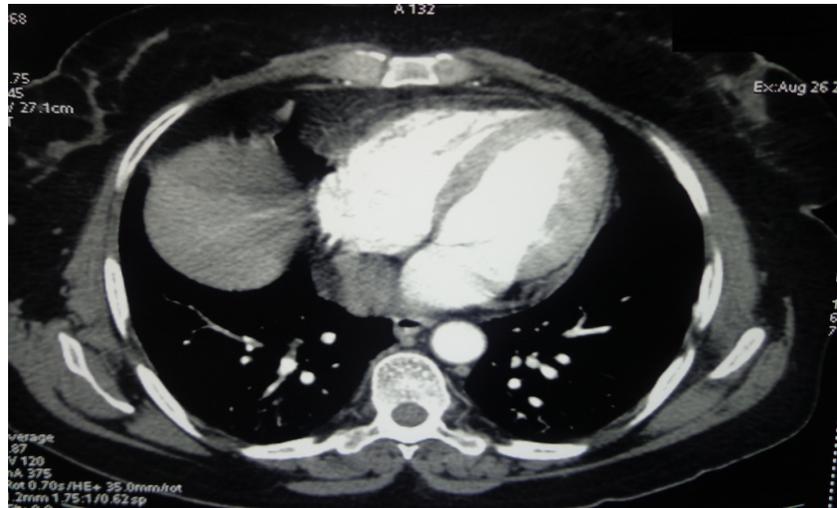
Axial view of chest high resolution CT-scan without anomalies.
